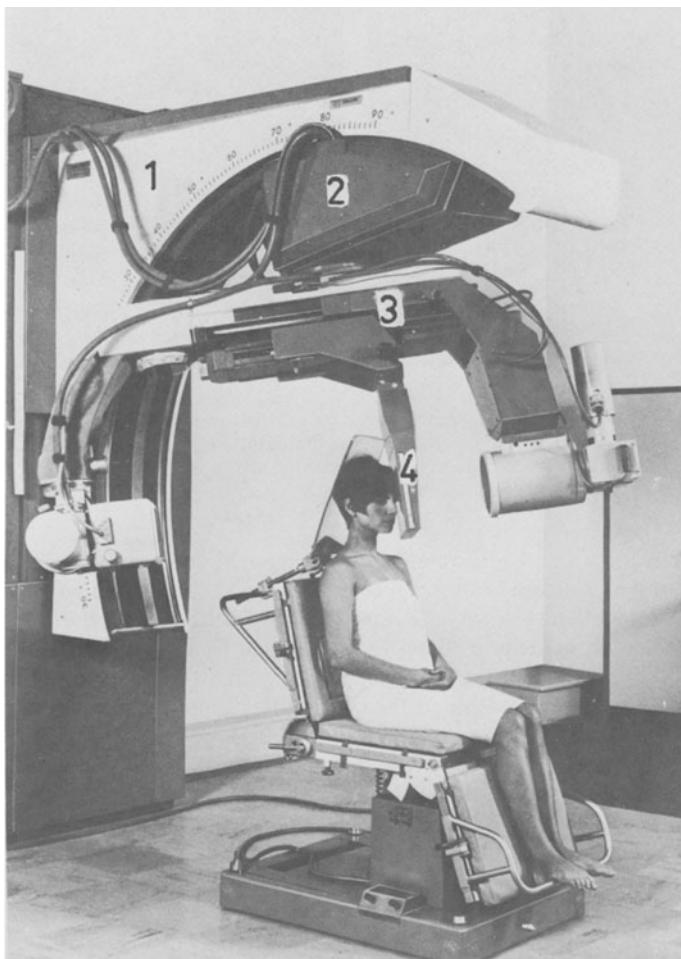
Special stand for neuroradiological examinations. 1. C-arch along which the trolley (2) can be moved; this allows the arm (3) which carries the X-ray tube and image intensifier with television combination to be rotated; 4. cassette.
